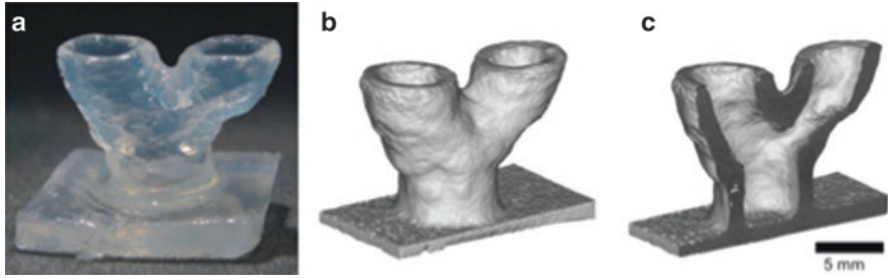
(a) Photograph of the bifurcation model. (b, c) CT images of the vascular construct in full and in sectional view (scale bar, 5 mm). Blaeser, A., et al., Biofabrication under fluorocarbon: a novel freeform fabrication technique to generate high aspect ratio tissue-engineered constructs. *Biores Open Access*, 2013. 2(5): p. 374-84 [2, 14]
